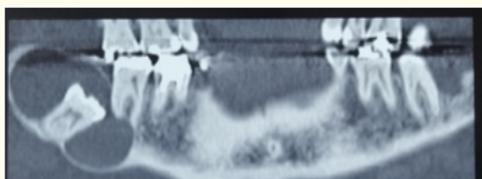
Orthopantomogram showing well-defined unilocular radiolucency, in the right angle of mandible.
